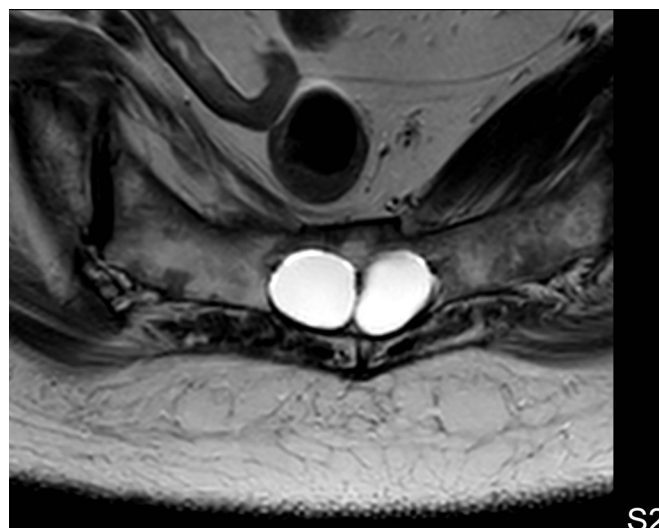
MRI Axial cut at S2 Level.
